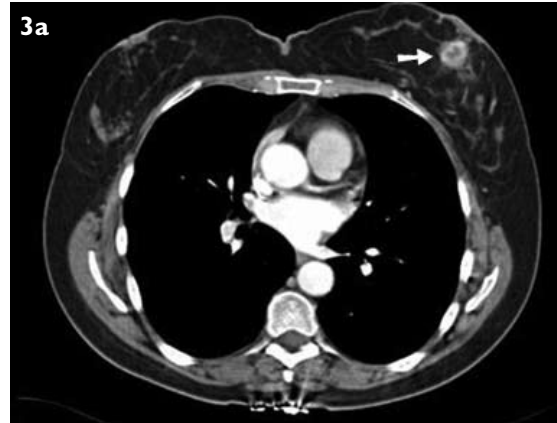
Axial CT images show (a) a tumour in the left breast (arrow) and (b) a tumour of the left kidney.
